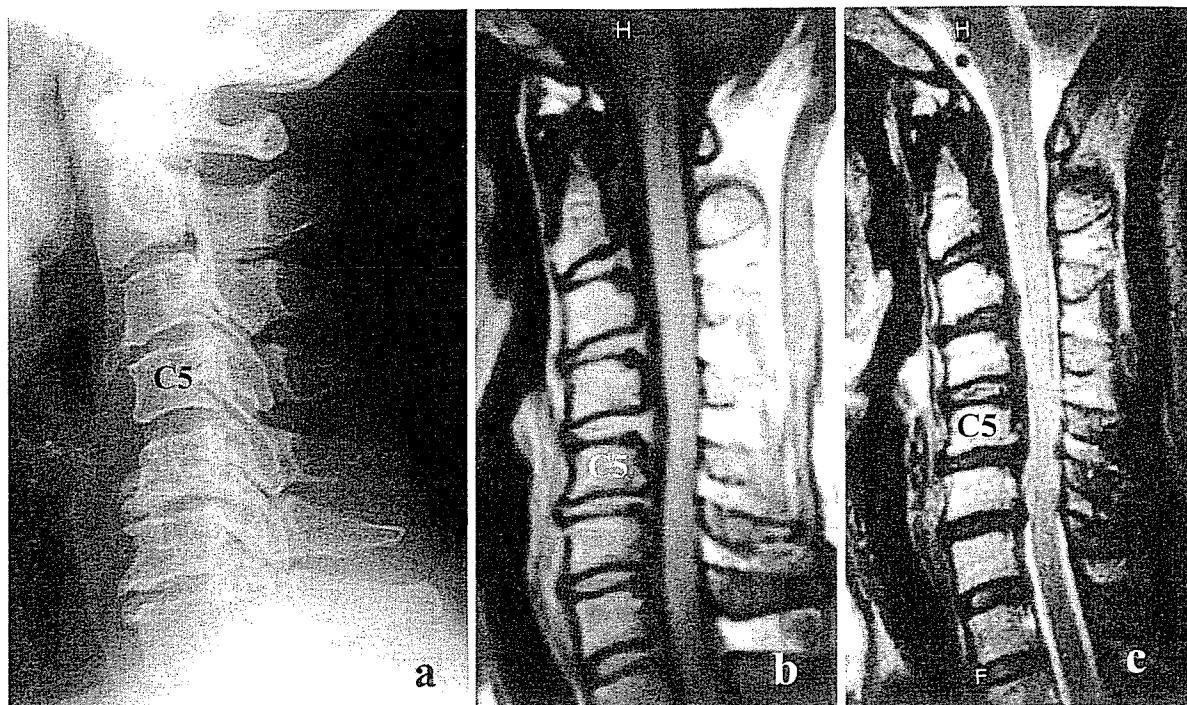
Mixed type-OPLL in a 50-year-old woman. a Radiograph shows mixed-type OPLL from the C2 to C6 levels. T1-weighted (b) and T2-weighted (c) MRI scans show mild spinal
